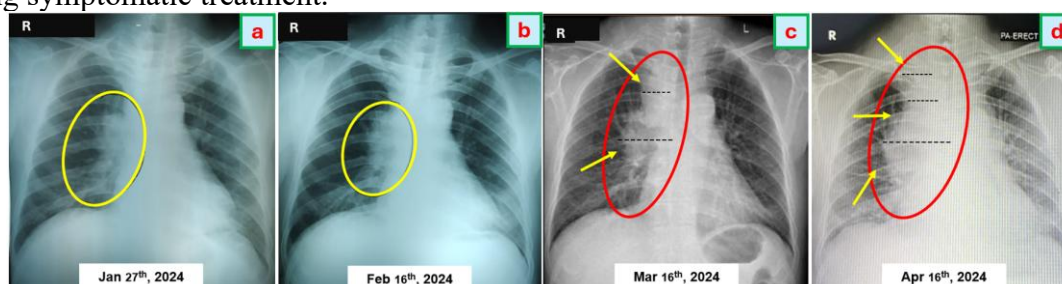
Serial Chest X-ray during Outpatient and Hospitalization
